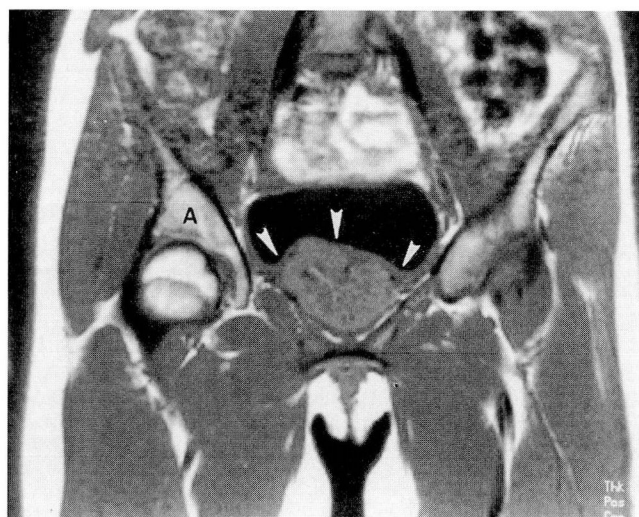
Coronal T1-weighted (TR 400 msec, TE 15 msec) MR image. The mass displaces the bladder wall (arrows) superiorly (A = acetabulum).
